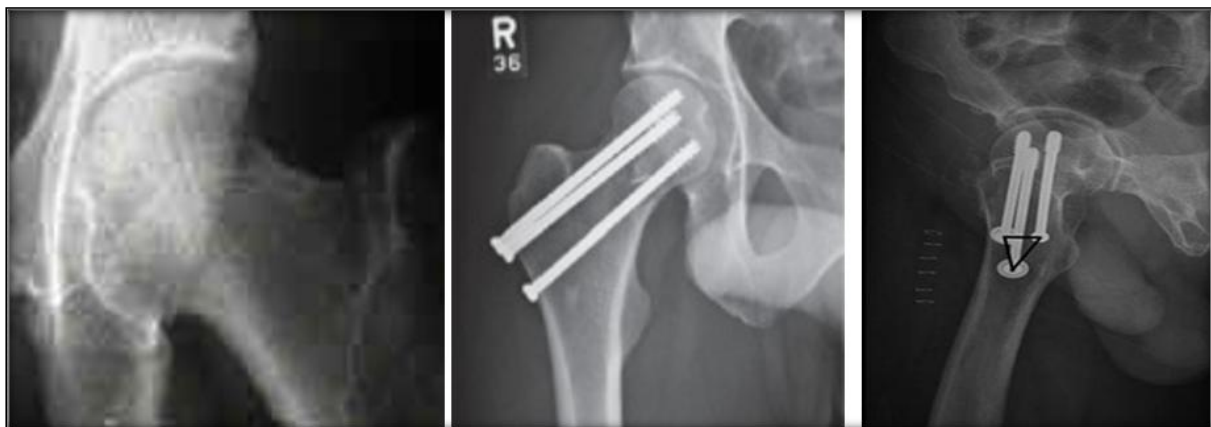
showing post-operative X-rays after technique
